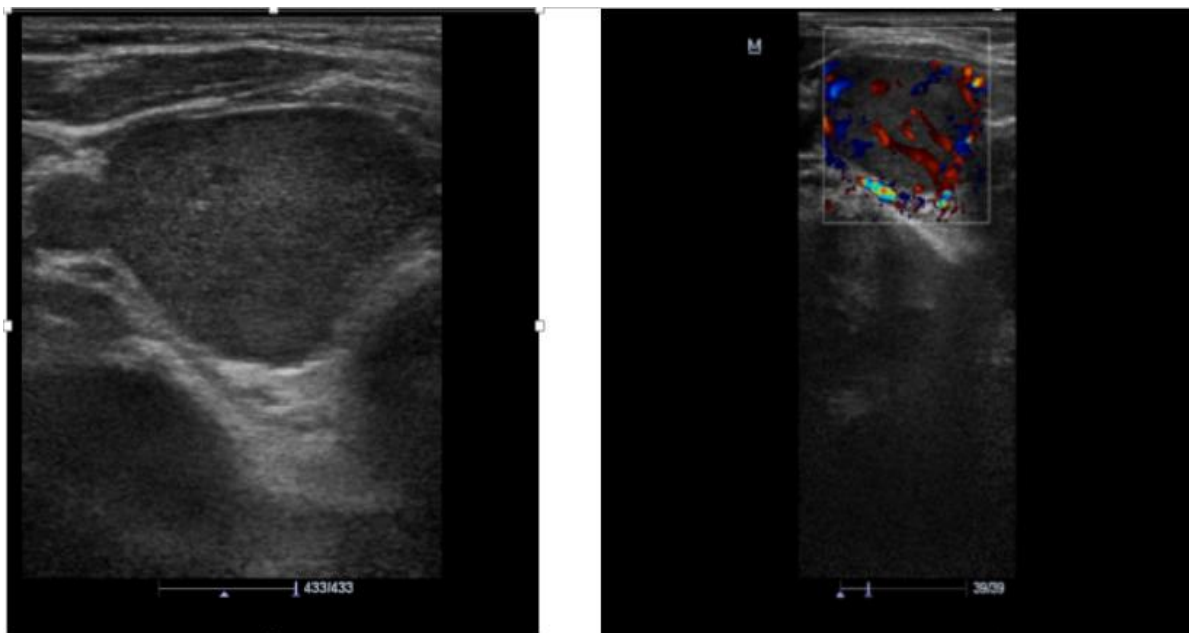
a) Gray scale & (b) Colour Doppler USG image showing hypoechoic solid nodule with regular margins and absent peripheral halo, showing intranodal as well as perinodal. USG diagnosis of malignant nodule was made. However proved to be colloid nodule of thyroid on FNAC. (False Positive)
